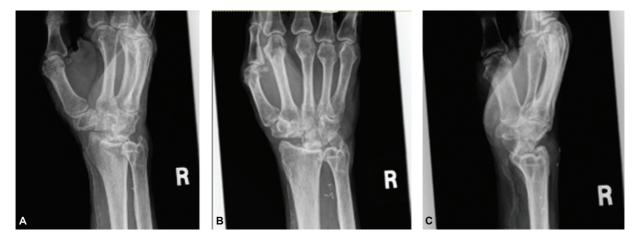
The preoperative (A) oblique, (B) anteroposterior, and (C) lateral X-rays demonstrated flattening of the proximal aspect of the capitate with increased sclerosis secondary to impaction against the radial articular surface.
